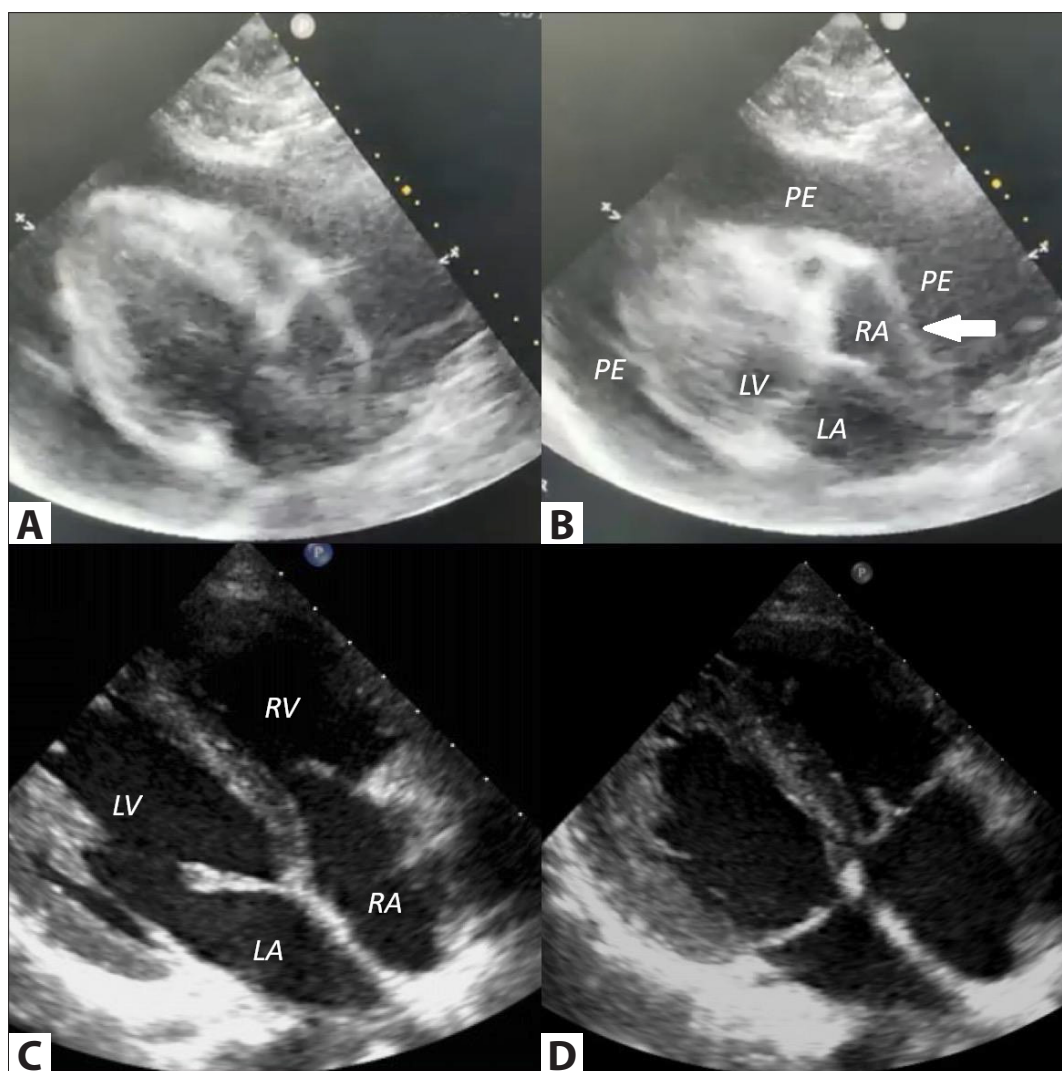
The patient's parasternal four-chamber views: (A,C). During ventricular diastole (B,D). During ventricular systole. The right atrial wall is markedly compressed (B – white arrow) and excessive pericardial effusion is observed with the free movement of the heart (A,B). After the treatment is completed and the patient's pericardial effusion has resolved (C,D), the atria and pericardium appear normal (D).
